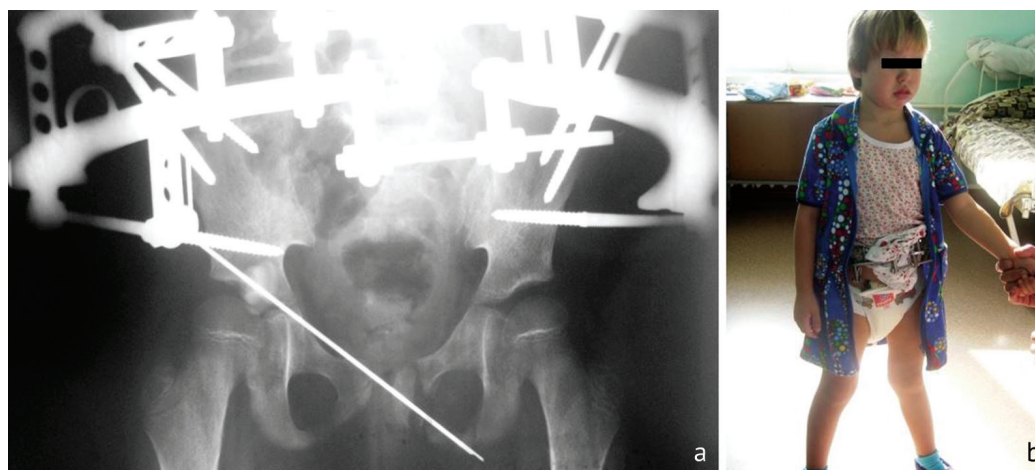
The patient 4 weeks after the operation before dismantling the external fixation device: *a* X-ray of the pelvis; *b* photo during treatment
